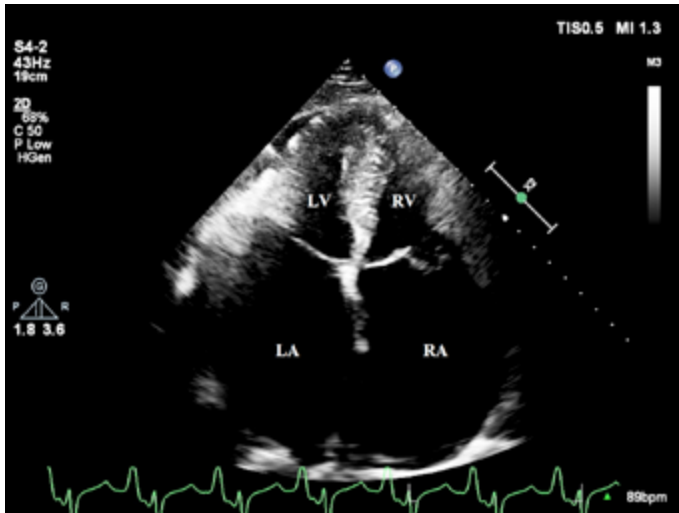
Transthoracic echocardiography from the apical four-chamber view showing severe biatrial dilatation.
